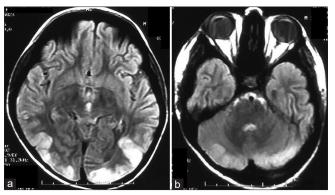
Magnetic resonance imaging (MRI) of the patient showing FLAIR hyperintensities in the bilateral parieto-occipital region (a) and bilateral cerebellar hemispheres (b)
